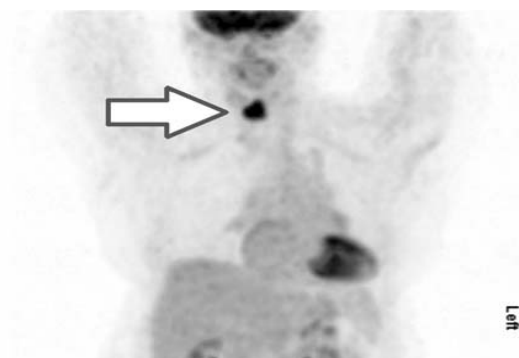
MIP from PET/CT shows the area of uptake
